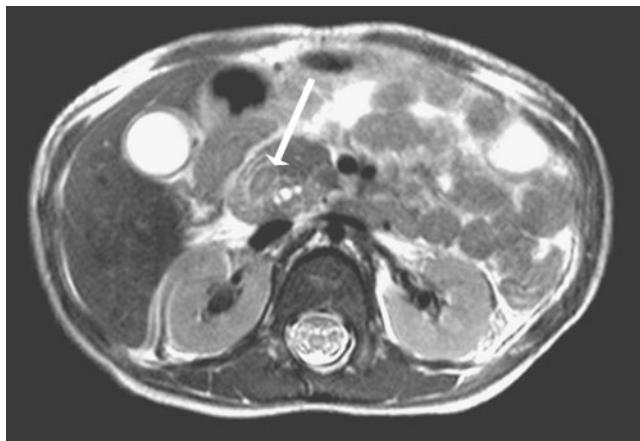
Axial T2-W MRI through the pancreatic head
